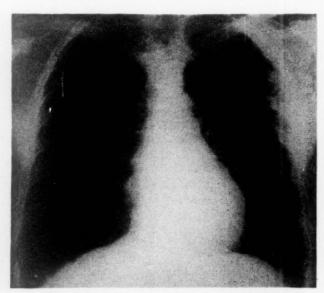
Case I. Roentgenogram of the chest taken on February 13, 1957, showing slight nodularity of the bronchopulmonary markings.
